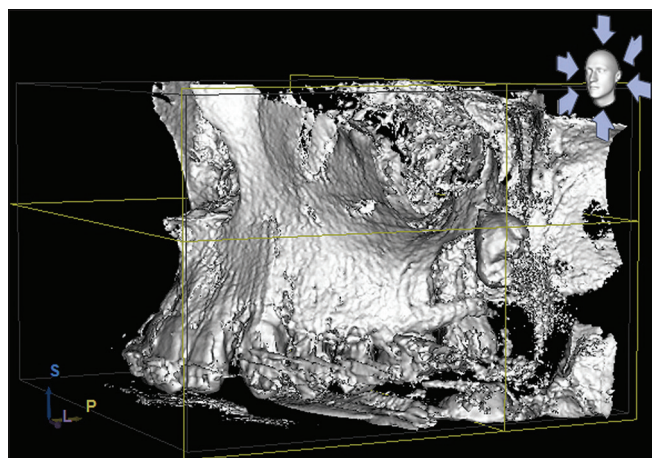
The three-dimensional cone beam computed tomography reconstruction.
